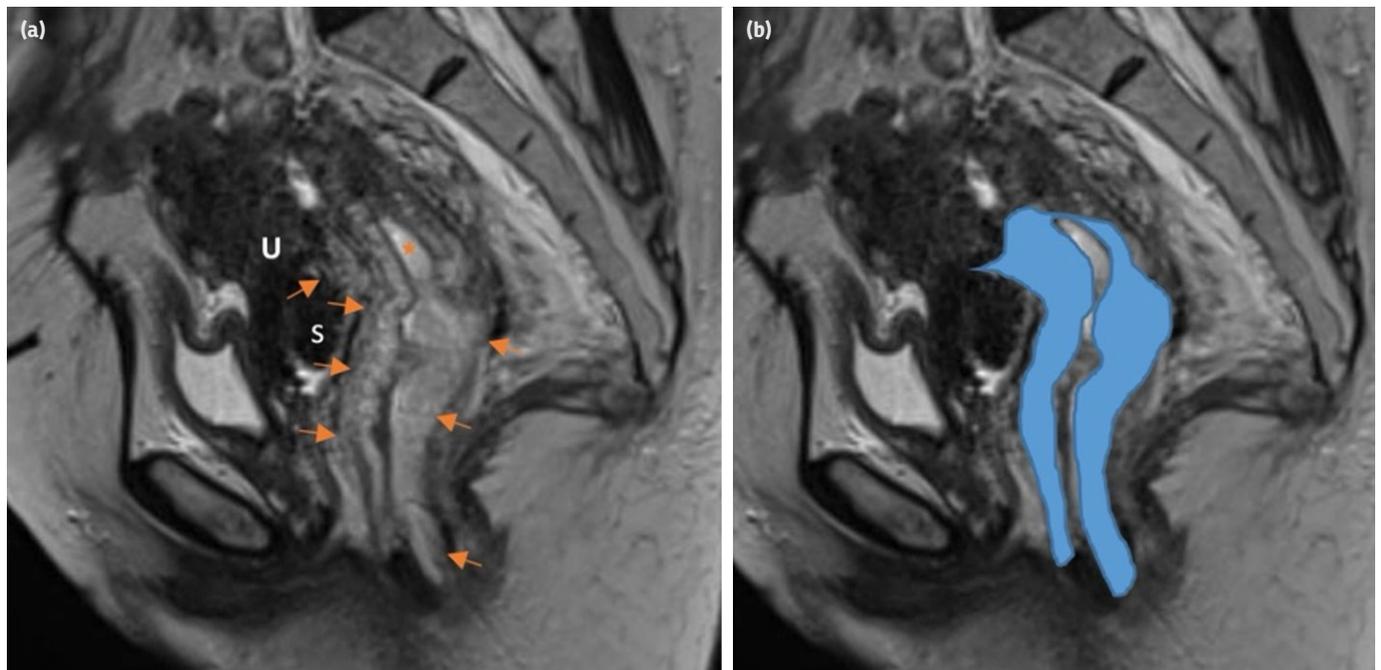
T4b rectal tumor (a, b). The patient, 46 years old, was diagnosed with mucinous components in her adenocarcinoma. Nine weeks following chemoradiotherapy, a high resolution T2 sagittal MRI was acquired. Orange arrows indicate the apparent invasion of the uterine corpus anteriorly and the anal canal caudally by the tumor tissue. Tumor borders are shown in blue (b)
